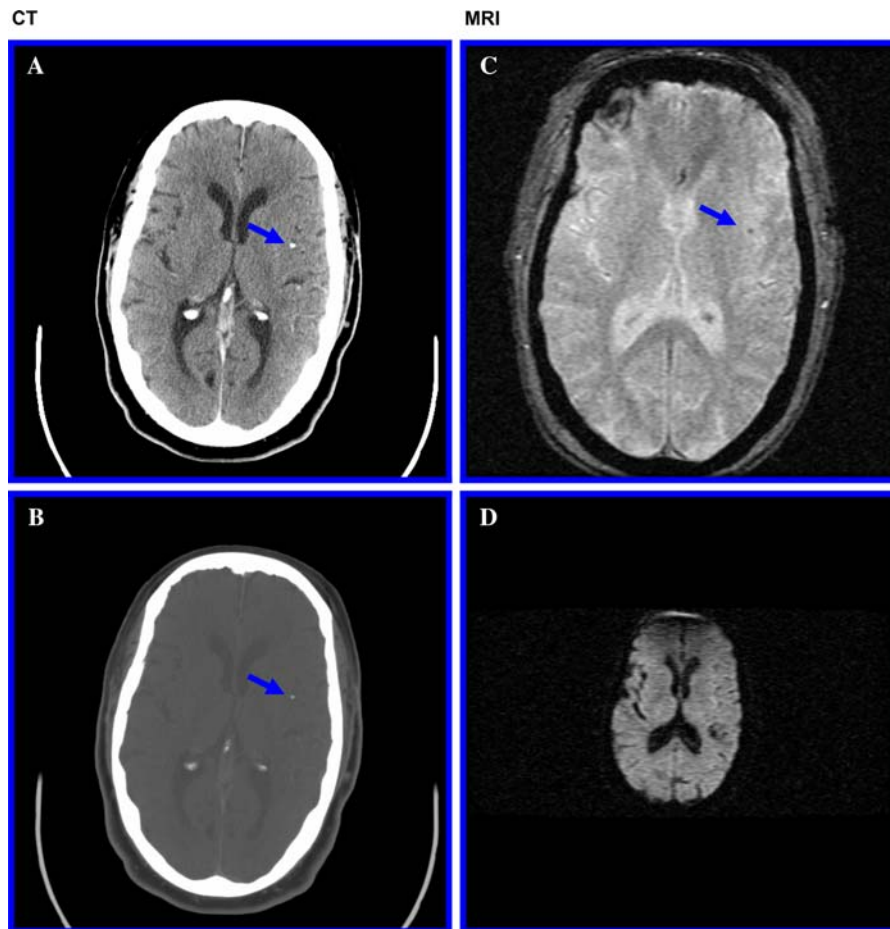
Post-coronary catheterization CT image of the head demonstrates a rounded 3-mm focus of hyperdensity (arrow) near the Sylvian point, at or near the junction of the M2–M3 vascular distribution (Soft-tissue, a; Bone, b). MR imaging was performed
